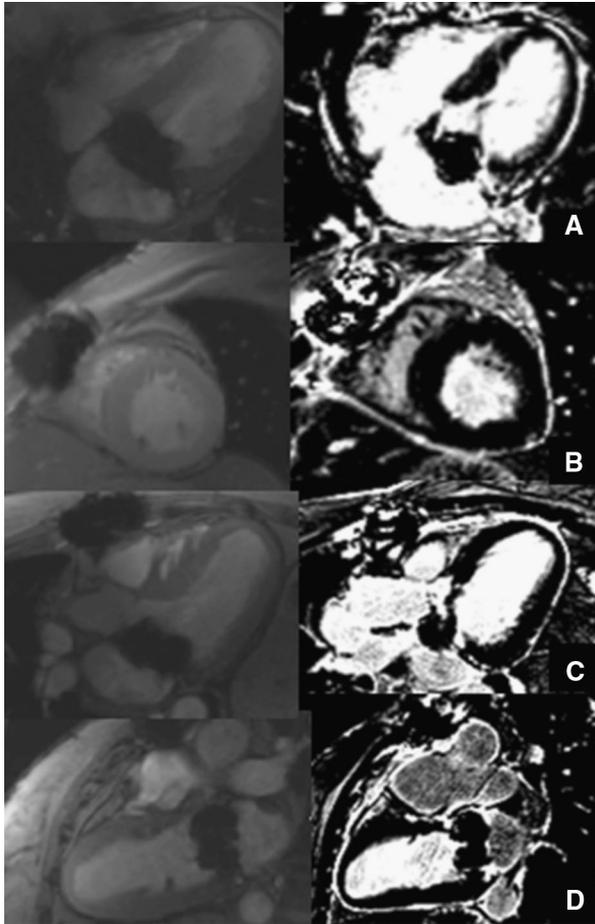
Cardiac magnetic resonance imaging diastolic still cine and delayed-contrast images 4-chamber (A), short-axis (B), long-axis frames (C, D). The left ventricle was normal in size with moderate-severely reduced systolic function. Paradoxical septal motion was seen with LBBB and post cardiac surgery, otherwise the wall motion was globally hypokinetic. There was significant local susceptibility artifact due to bioprosthetic mitral valve. There was no significant mitral regurgitation. The right ventricle was normal size and systolic function. On delayed-contrast images, there were no areas of late gadolinium enhancement to suggest myocardial inflammation or fibrosis.
